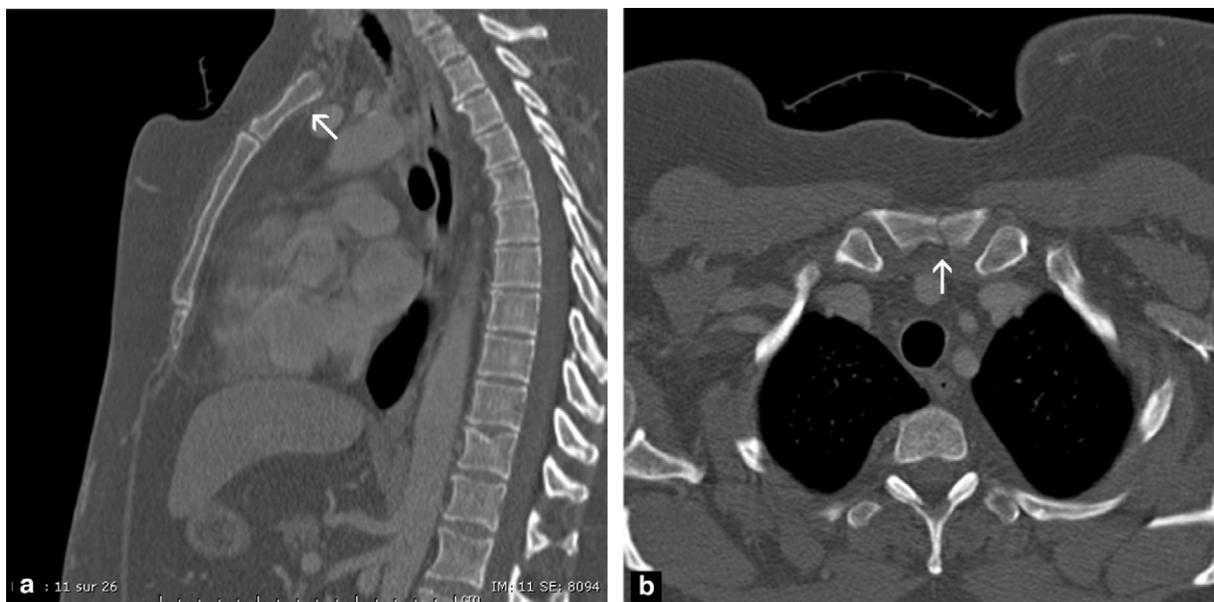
Clinically unsuspected sternal injury (original prescribing intent: no scan): axial slice (a) and sagittal reconstruction (b) of the chest in bone window showing a non-displaced manubrial fracture (white arrow). Discovery of such injuries systematically leads to performance of an echocardiogram to search for associated myocardial injuries.
